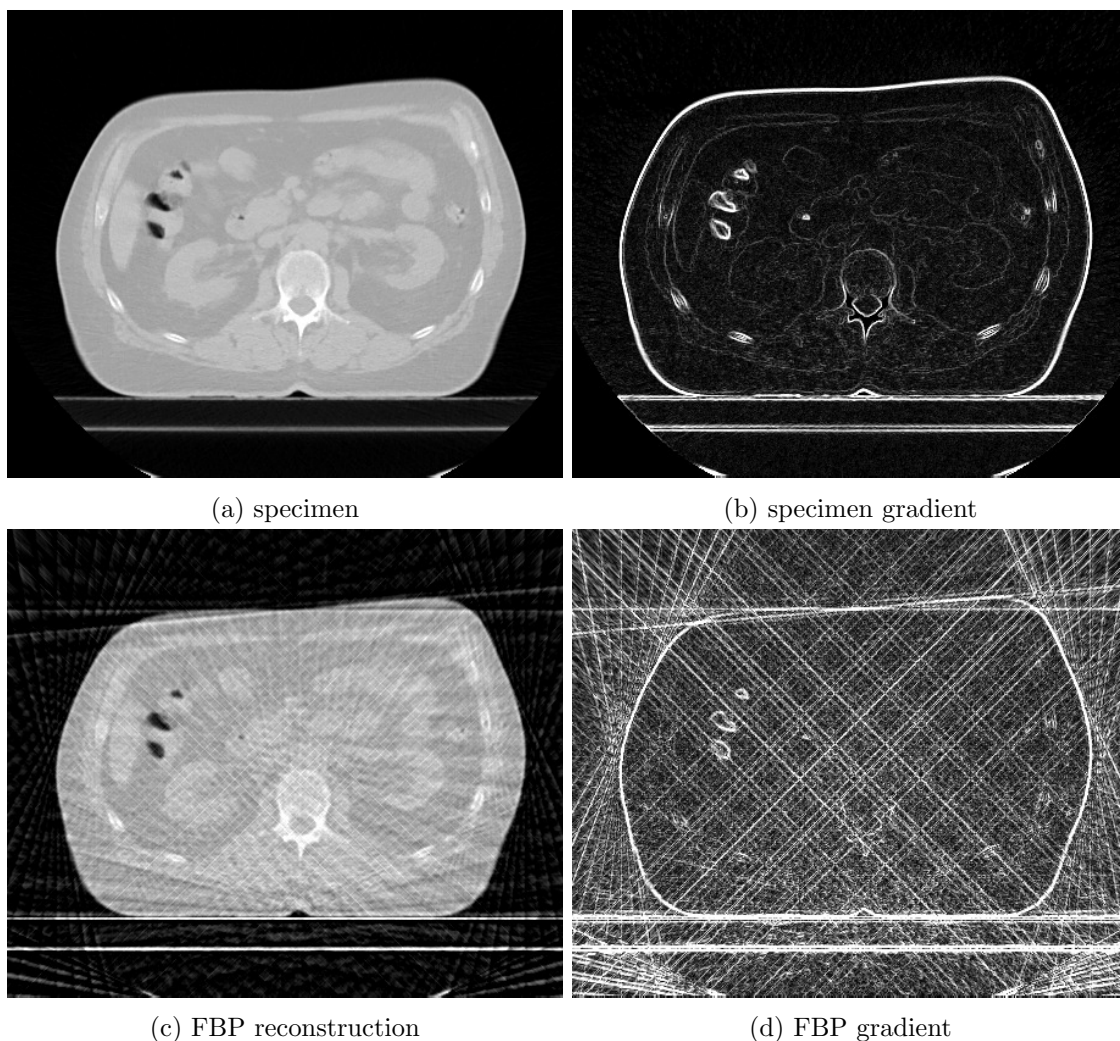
Gradient sparsity from high quality CT image and crude FBP reconstruction. The data was obtained from a lung segmentation challenge [4] on the Cancer Image Archive [5].
